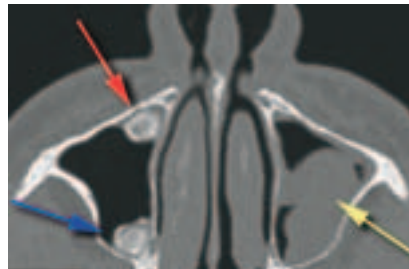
CT Axial 40 reveals anterior lesion (red arrow), posterior lesion (blue arrow), and pathology in left maxillary sinus (yellow arrow).
